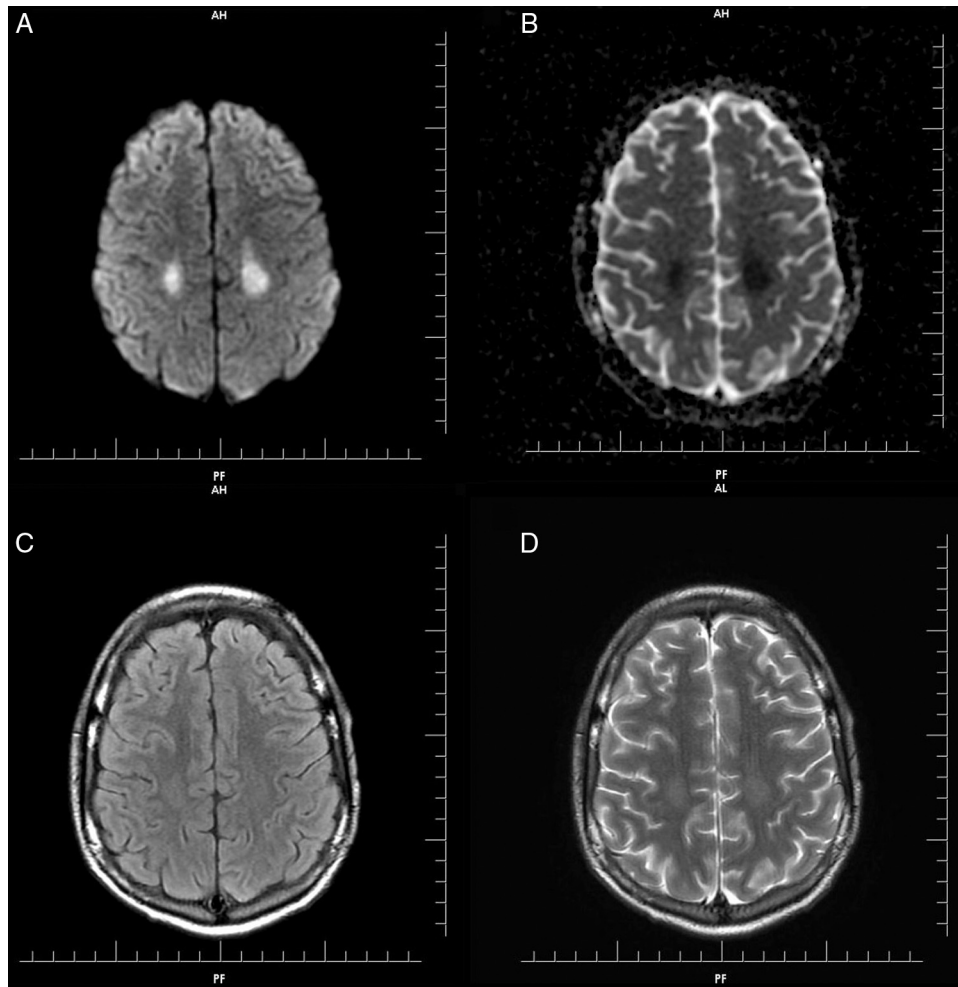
(A) Diffusion weighted imaging (DWI): symmetrical hyperintense signal in parietal lobe white matter, neither cortical area nor deep gray matter structures were affected. (B) Decreased apparent diffusion coefficient (ADC): symmetrical hyperintense signal. (C) Axial T2/FLAIR image: discrete symmetrical hyperintense signal in parietal lobe white matter. (D) Axial T2: discrete symmetrical hyperintense signal in parietal lobe. No abnormality was observed in T1.
